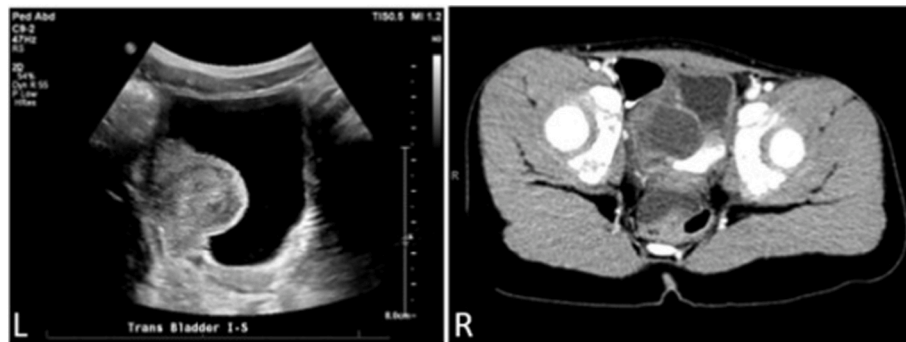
Left: Transverse representative ultrasound image demonstrating intraluminal bladder mass. Right: Axial view of bladder mass on CT with oral and intravenous contrast.
